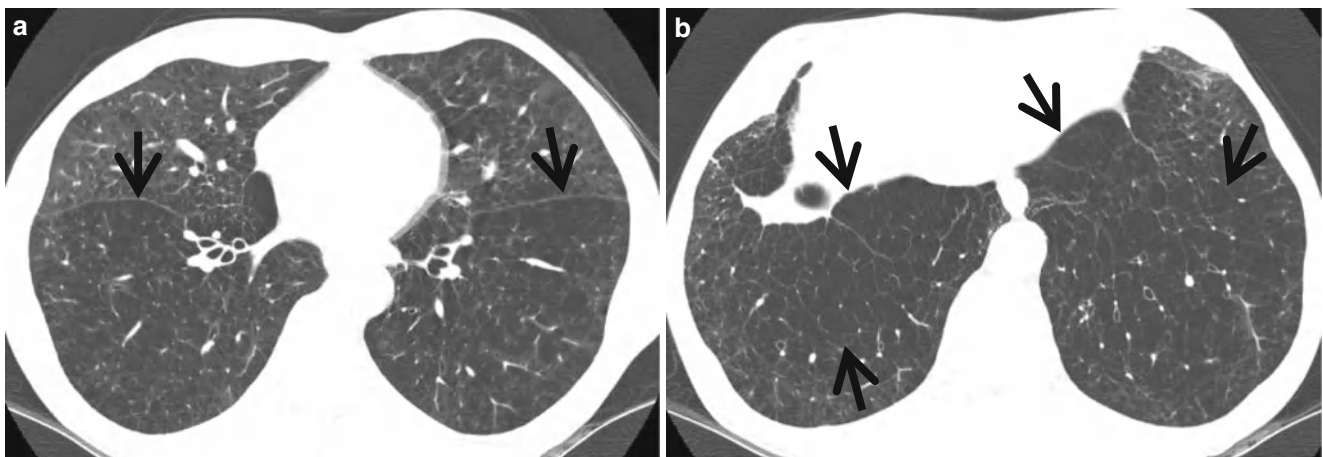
Panlobular emphysema in a 55-year-old man. (a, b) Lung window images of thin-section (1.0-mm section thickness) CT scans obtained at levels of right inferior pulmonary vein (a) and liver dome
